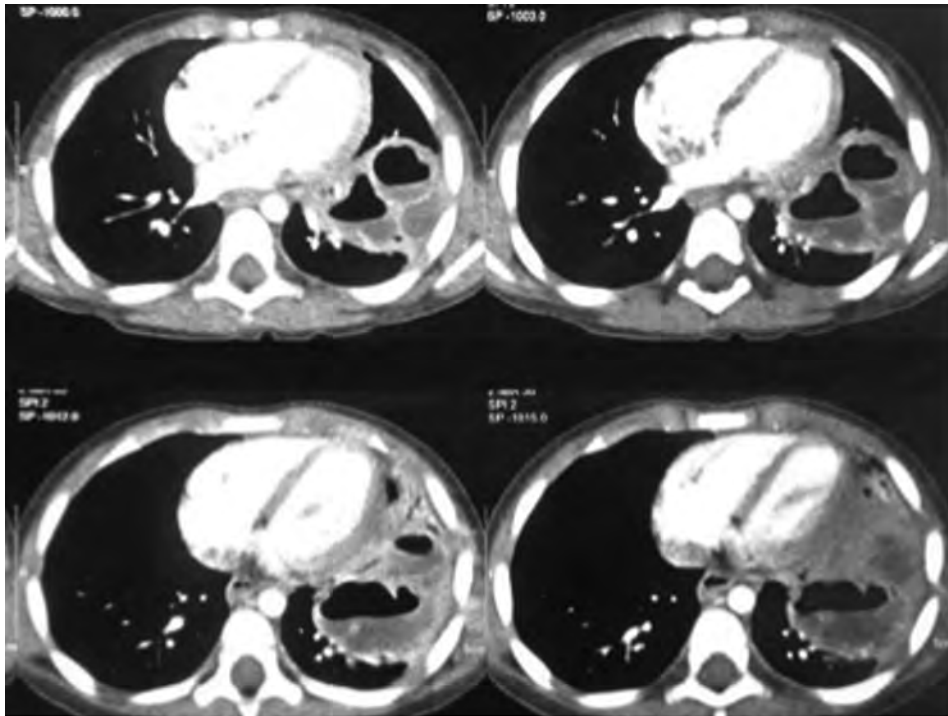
Computed tomography chest scan at diagnosis (Case 2) demonstrating a necrotic area with thin-walled cavities within the left lower lobe. Necrotizing pneumonia, with no evidence of pleural effusion
